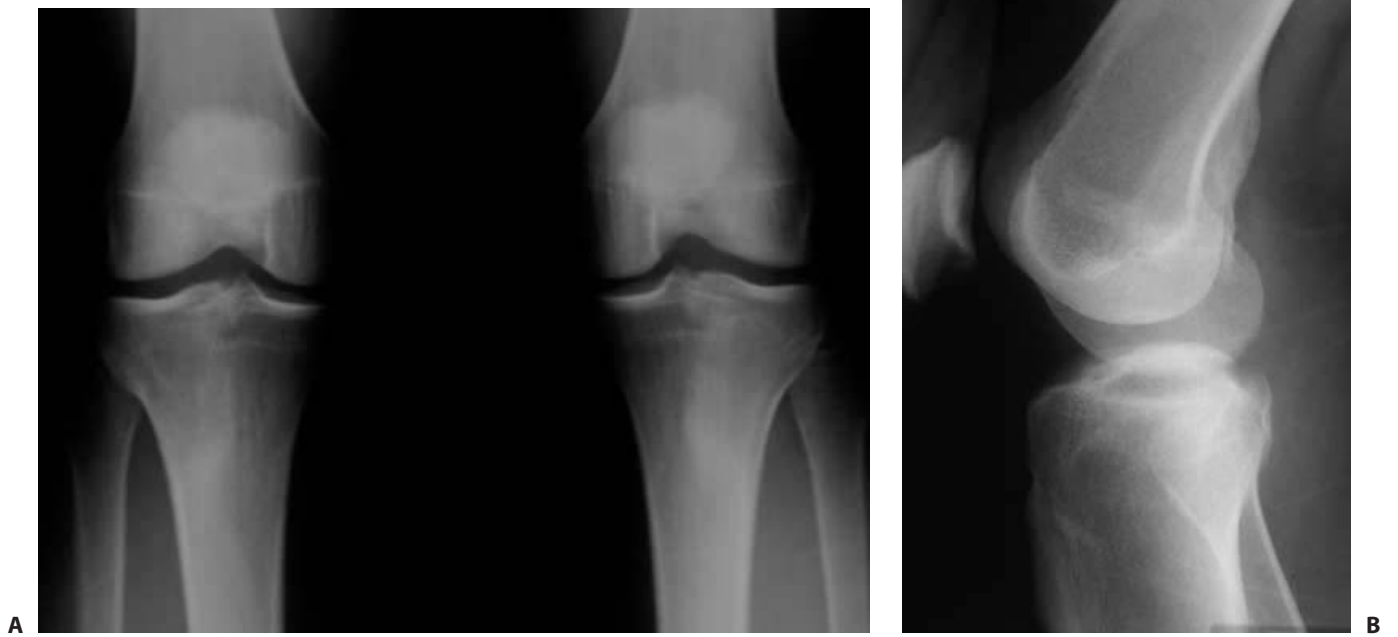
Forty-five-degree flexion weight-bearing posteroanterior (A) and lateral (B) radiographs demonstrate no abnormalities.
